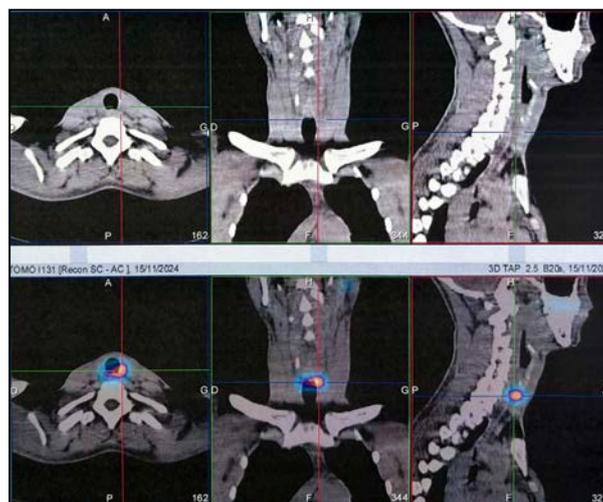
Cervico-mediastinal SPECT CT showing a single focus of radioiodine uptake related to one thyroid residue.
